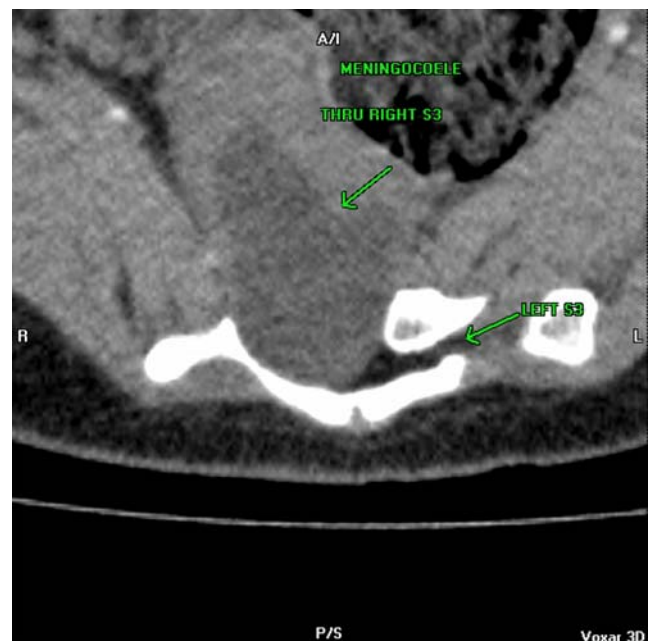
Axial computed tomography through S3 level
